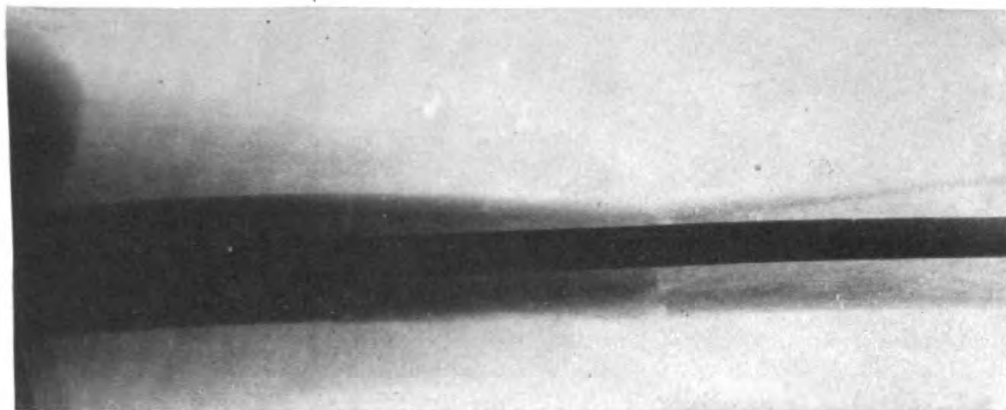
Case 4. Postoperative anterior-posterior x-ray.
